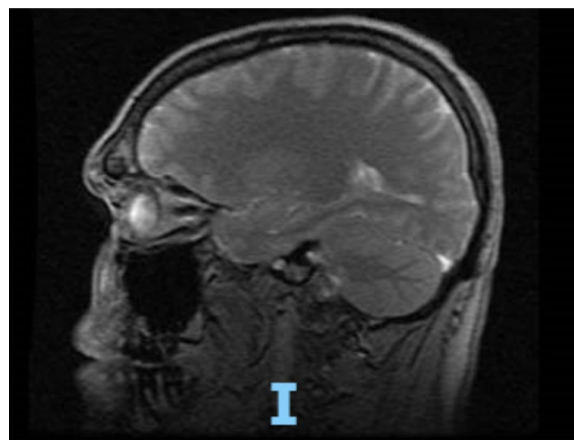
MRI showing nodular leptomeningeal enhancement
